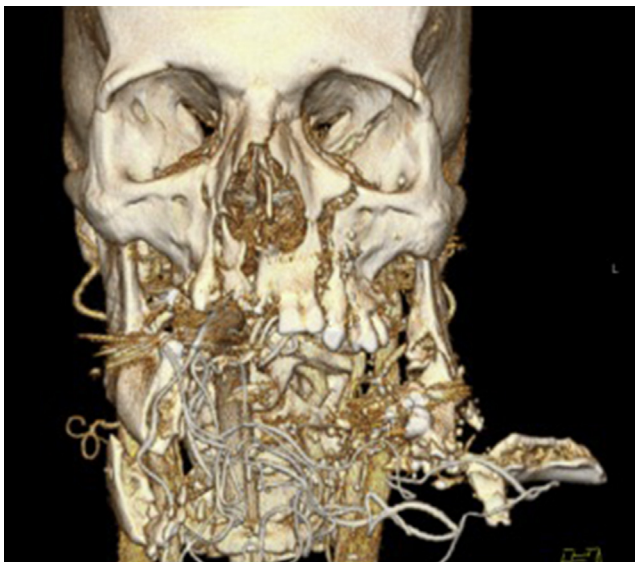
Three-dimensional reconstructed computed tomographic imaging shortly after the patient's arrival to the emergency department. Almost complete destruction of the mandible noted with severe displacement of the remaining fragments.
